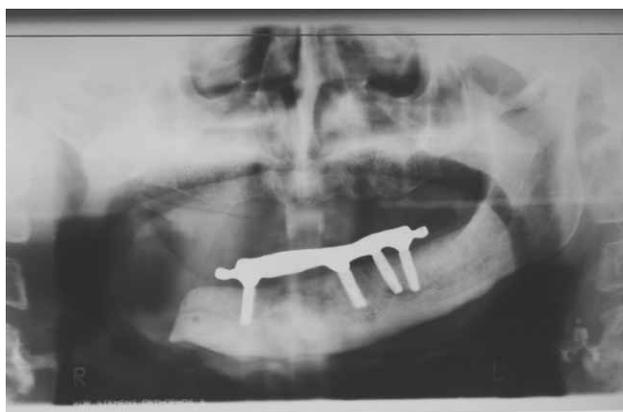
The panoramic radiograph of implants and screwed bar.
